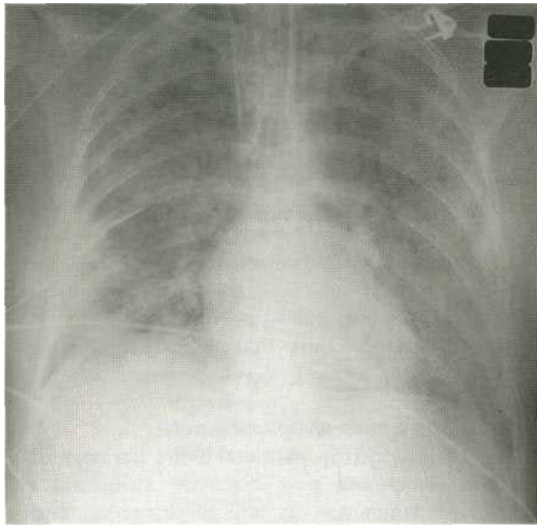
Chest radiograph appearances in acute respiratory distress syndrome. Bilateral diffuse alveolar shadowing with air bronchograms and no cardiac enlargement.
